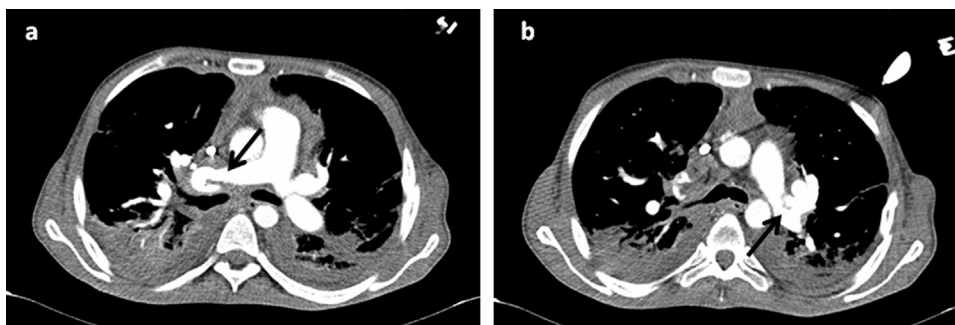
Axial image from contrast-enhanced computed tomography scan of the chest showing a filling defect compatible with thrombus (arrows). The size of lesions shown are (a) 7 × 10 mm in right pulmonary artery and (b) 14 × 5 mm in the anastomosis of left pulmonary artery.
